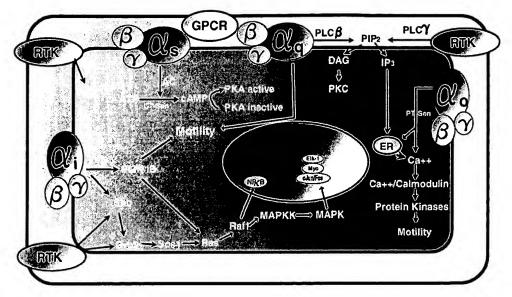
Intracellular signaling pathways in NK cells. Multiple signaling pathways are activated upon ligation of receptors present on these cells. The signals are transmitted through either RTK or GPCR. The $[Ca^{2+}]_i$ pathway can be activated by either RTK/PLC_γ or G_q /PLCβ. This will result in the hydrolysis of PIP₂ into two second messengers: IP₃, which induces the mobilization of $[Ca^{2+}]_i$ from the ER, and DAG, which activates PKC. The p21^{ras}/MAP kinase pathway results from the activation of either RTK or GPCR. MAP kinases phosphorylate various nuclear binding proteins such as c-Jun/Fos, c-Myc, and ELK-1, among others. PI-3K is present in one of two forms: PI-3KIA (p110 and p85) binds the receptors upon tyrosine phosphorylation, whereas PI-3KIB (p110 and p101) binds the GPCR upon activation. Abbreviations for Figs. 1 and 2: AC, adenylyl cyclase, cAMP, cyclic adenosine monophosphate, βARK, beta adrenergic receptor kinases, CT, cholera toxin, DAG, diacyl glyceride, ER, endoplasmic reticulum, GPCR, G-protein-coupled receptors, Grb-2, growth factor receptor bound protein 2, IP3, inositol 1,4,5,-trisphosphate, MAPK, mitogen-activated protein kinase, PI-3K, Phosphoinositide-3 kinase, PIP2, phosphatidylinositol bisphosphate, PKA, protein kinase A, PKC, protein kinase C, PLC, phospholipase C, PT, pertussis toxin, RTK, receptor tyrosine kinases, Shc, Src homology and collagen, SOS, son of sevenless.
